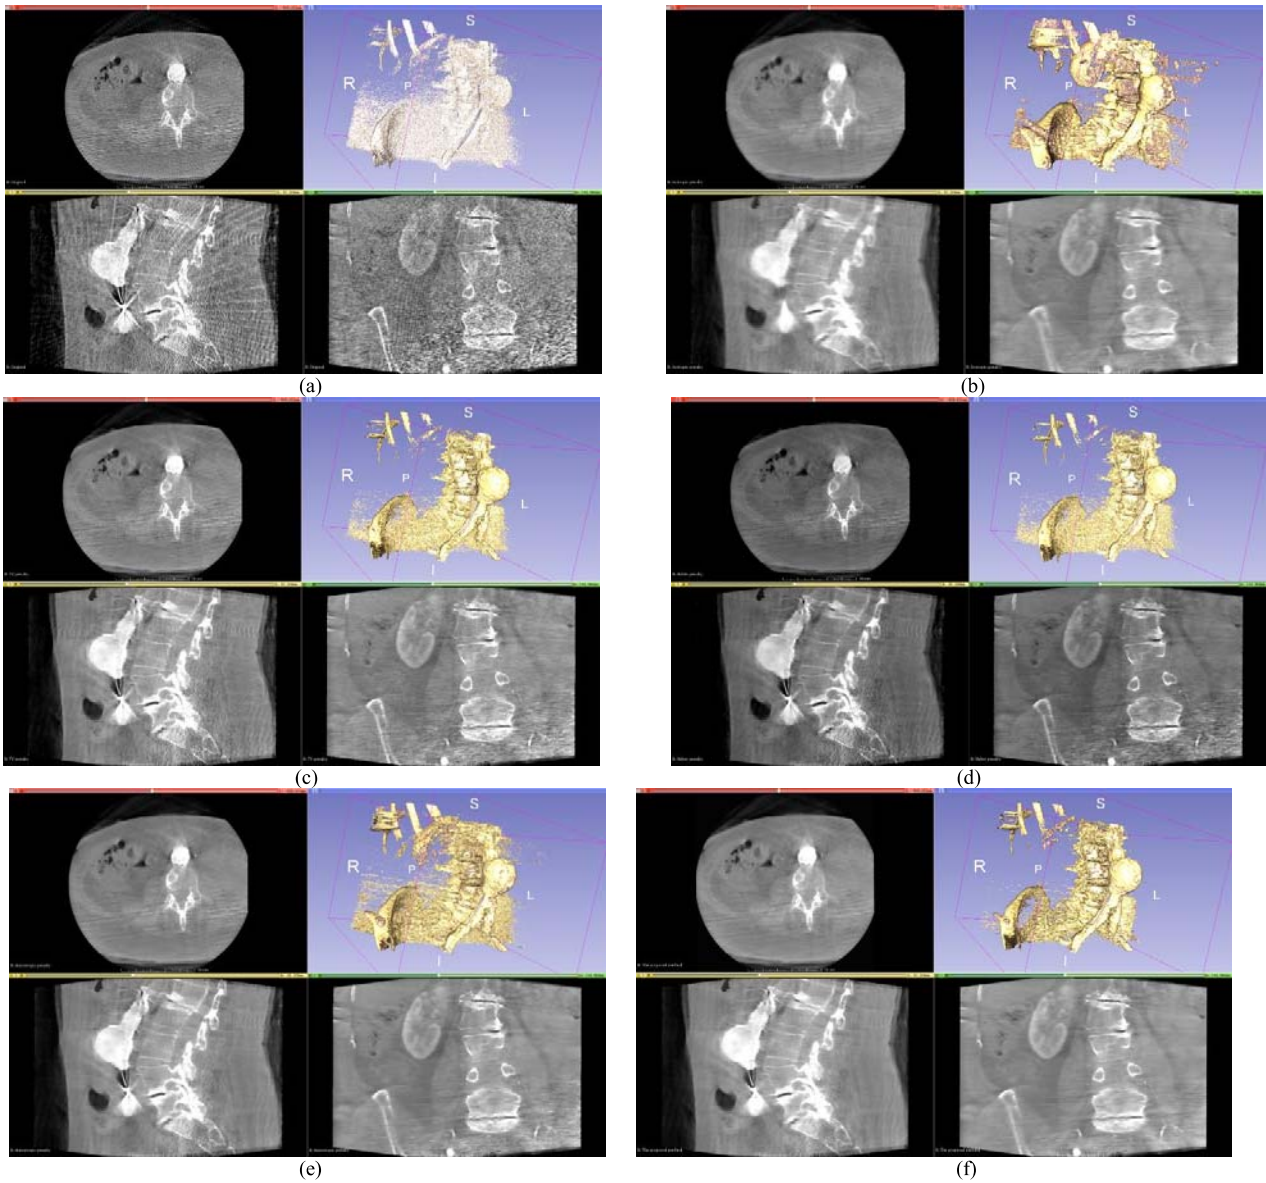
Pre-deployment CBCT: (a) original CBCT, (b) result from the isotropic penalty, (c) result from the TV penalty, (d) result from the Huber penalty, (e) result from the anisotropic penalty, (f) result from the proposed edge-preserving penalty.
